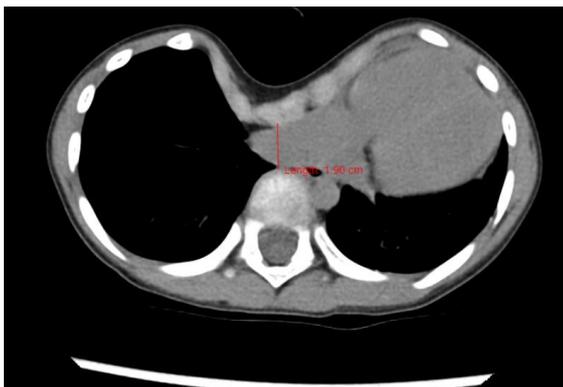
Preoperative chest CT showed significant depression at the lower end of the sternum. The minimum distance between the depressed sternum and the spine was less than 2cm, and the heart was obviously compressed and shifted to the left thoracic cavity.
